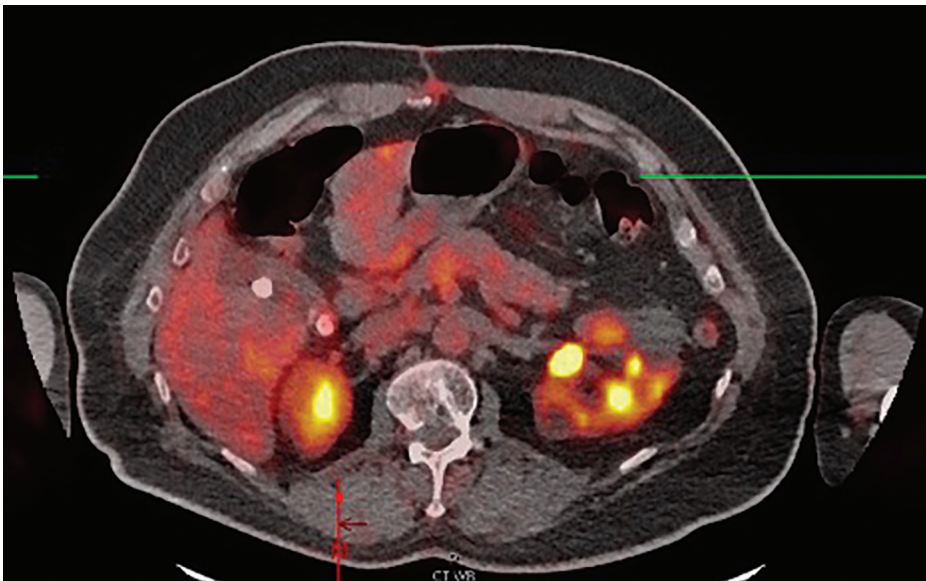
PET/CT imaging for the evaluation of laryngeal cancer.
